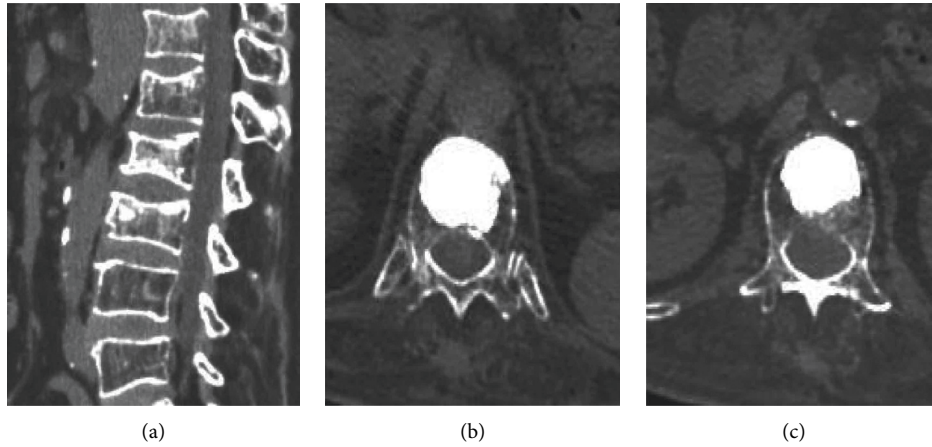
70-year-old female with compression fractures of thoracic 12 and lumbar 1 vertebral body. (a) Preoperative CT. (b, c) Postoperative CT of thoracic 12 and lumbar 1 vertebral body.
